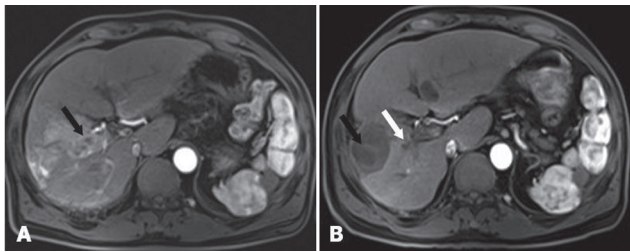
A 65-year-old male patient with hepatocellular carcinoma and portal vein tumor thrombosis. MRI imaging shows a 6-cm enhanced tumor (black arrow) and portal vein tumor thrombus mass (white arrow) in the right hepatic lobe. Fig B. MRI at six-month after three GSMs-TACE procedures shows the nonenhanced tumor (black arrow) and portal vein tumor thrombus (white arrow), indicating a complete response by mRECIST criteria.
